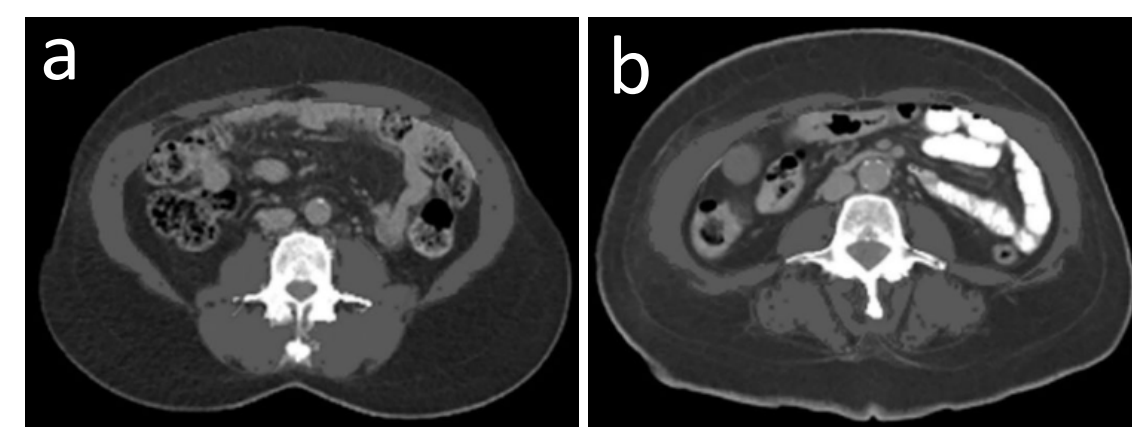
CT scans demonstrating difference in SMD (a > b) in CT scans from individuals with similar BMI and SMI. Adapted from Shachar et al., *Clinical Cancer Research*, 2017.
